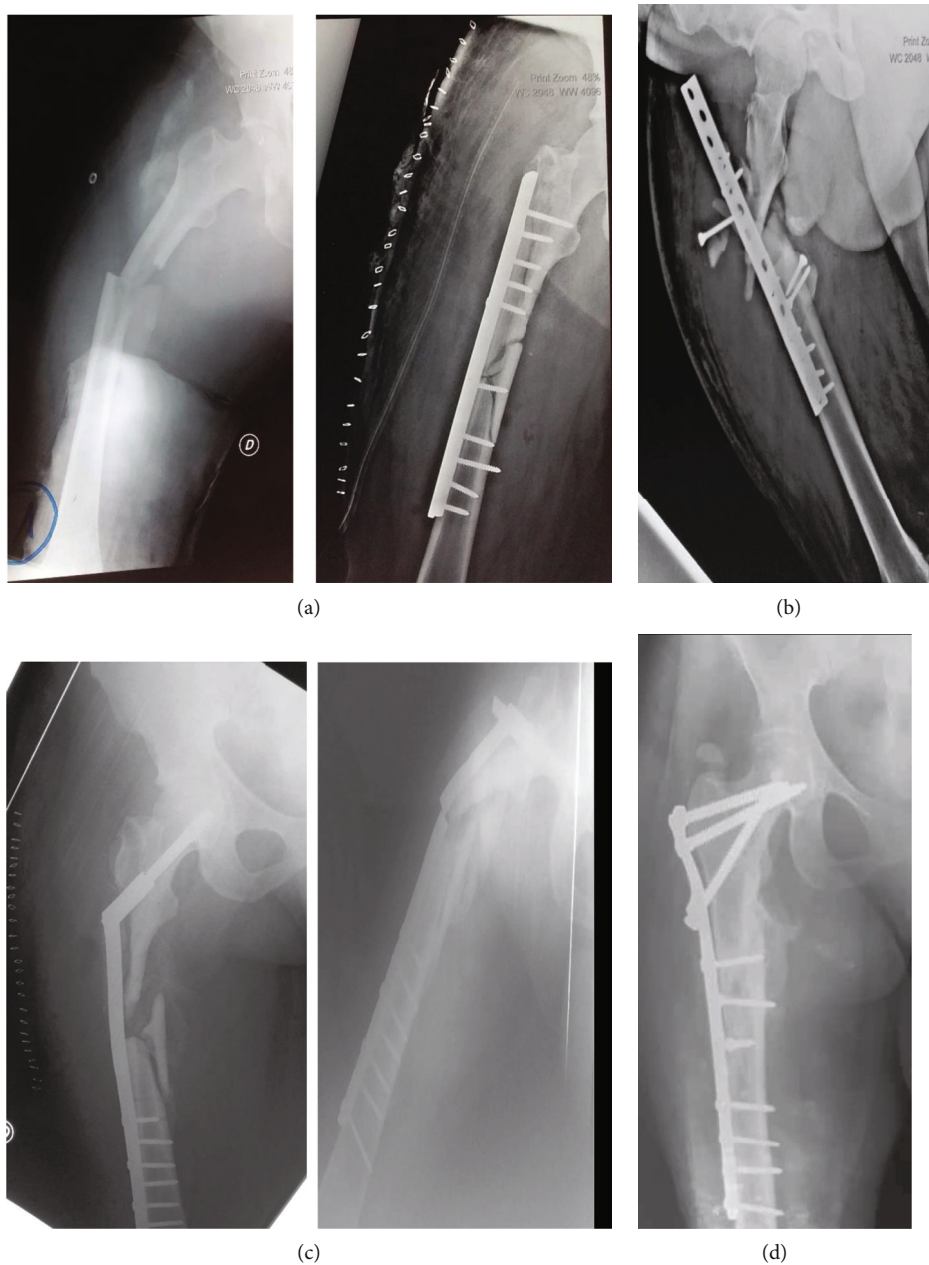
X-ray of case 1: ((a) subtrochanteric fracture; (b) missed fixation of DCP; (c) atrophic nonunion with fracture of the DHS system; (d) locked plate osteosynthesis).
